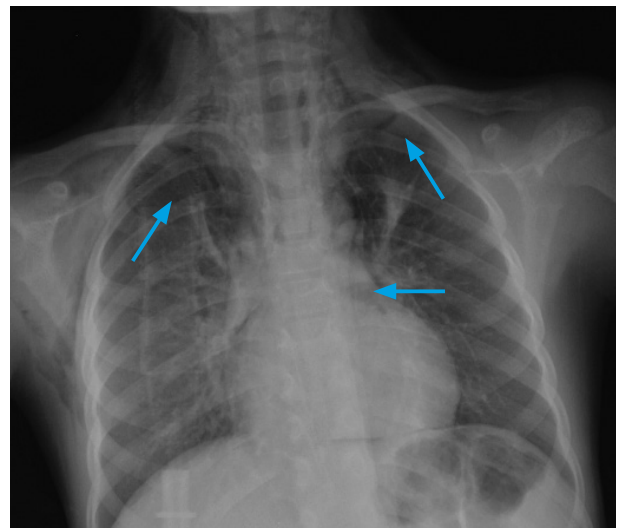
Chest X-Ray with pneumomediastinum and subcutaneous emphysema (arrows).
